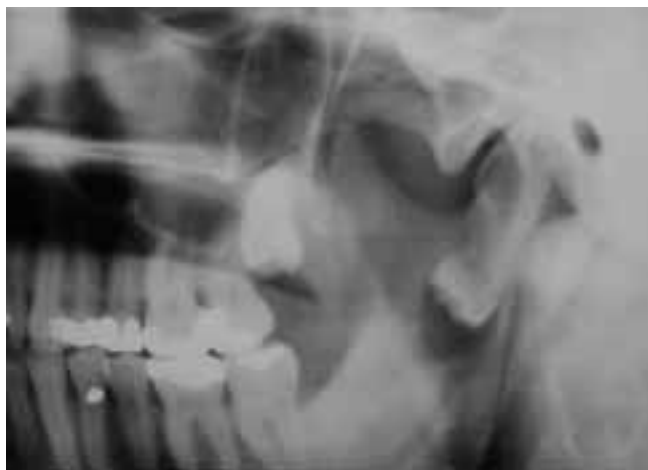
Panoramic x-ray showing the high dislocation of the left lower third molar into the condylar region
